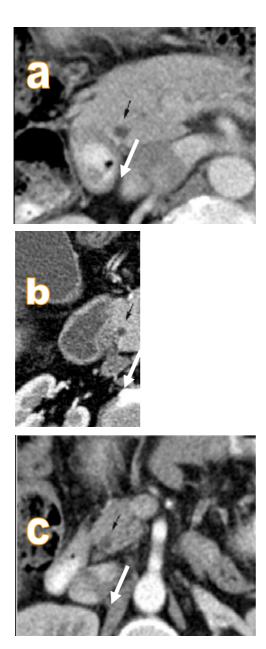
CT scans show the three possible anatomic relationships between the CBD (arrow) and the pancreas: (a) Partial coverage of the CBD by pancreatic tissue (b) Total coverage (c) No coverage (Mortele et al., 2006).
